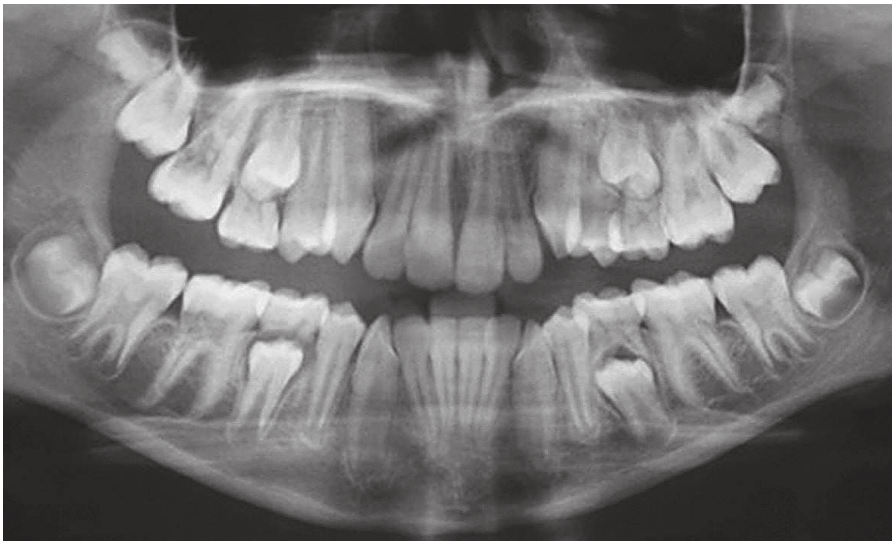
Third panoramic radiograph.
